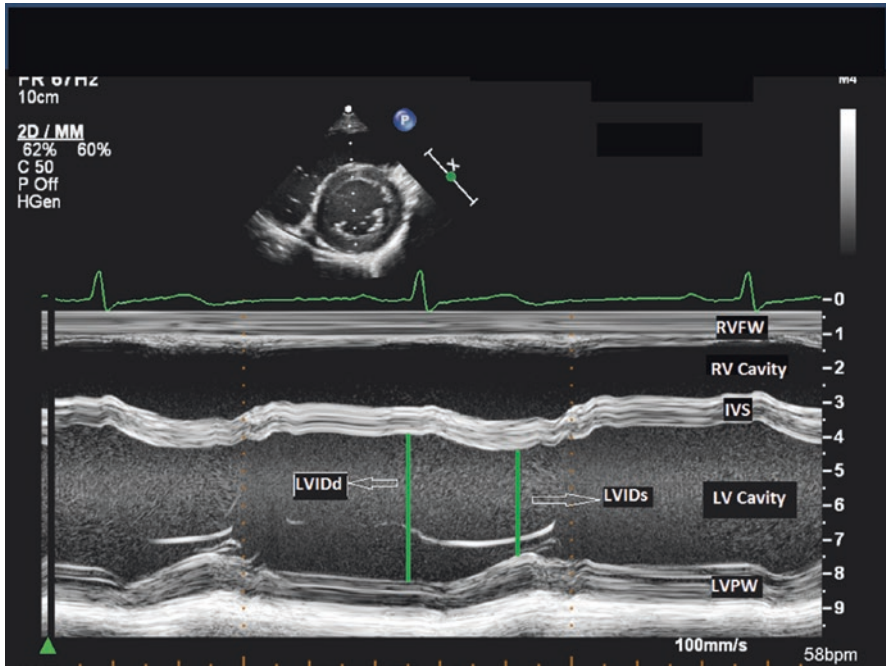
M-mode image obtained at the parasternal short axis at the level of the mitral papillary muscle. The shortening fraction is calculated by dividing the left ventricular internal diameter in diastole dimension by the left ventricular internal diameter in systole as measured by M-mode echocardiography. *RV FW* right ventricular free wall, *RV cavity*, *IVS* interventricular septum, *LV cavity*, *LV PW* left ventricular posterior wall, *LVIDd* left ventricular internal dimension in diastole, *LVIDs* left ventricular internal dimension in systole
